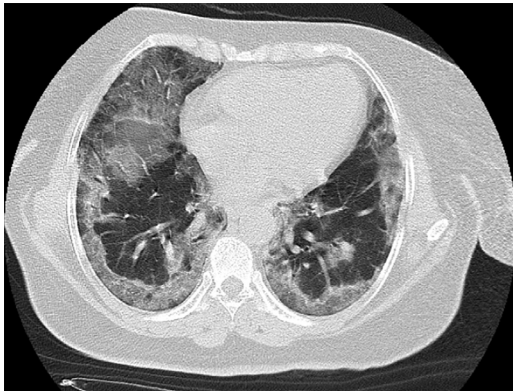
Chest CT Scan reveals diffuse bilateral peripheral patchy ground glass opacity with mild vascular dilation.
